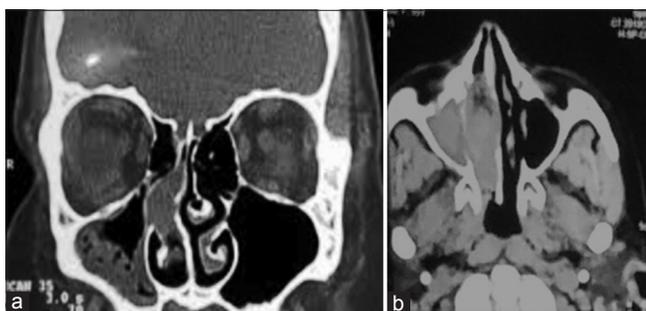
(a and b) Computed tomography scan, coronal and axial views showing a moderately enhancing mass in the right nasal cavity with extension to maxillary antrum
